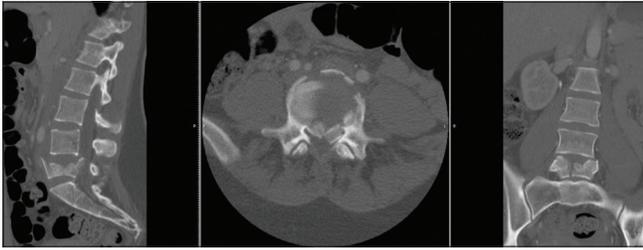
Pre-operative computed tomography scan showing L5 burst fracture with retropulsion into the canal.
